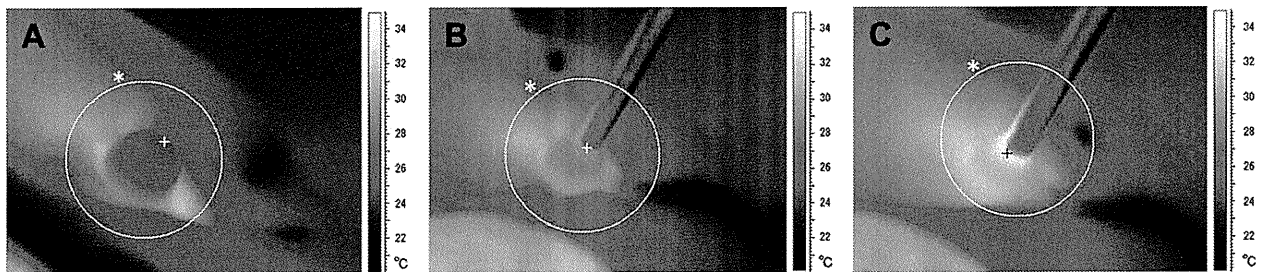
The thermographic images of ultrasound-treated eye by an infrared thermography. Temperature was expressed as a pseudo-color. (A) Control. The highest temperature within the circle (denoted by an asterisk) was 31.9°C and the temperature of the spot + was 24.4°C. (B) US exposure for 5 min under the condition: frequency of 1.0 MHz, duty cycle of 5.2%, pulse repetition frequency of 20 Hz and  $I_{SPPA,3}$  of 0.228 W/cm<sup>2</sup>. The highest temperature within the circle (denoted by an asterisk) was 31.2°C and the temperature of the spot + was 28.5°C. (C) US exposure for 5 min under the condition: frequency of 1.0 MHz, duty cycle of 100%, continuous wave mode and  $I_{SPPA,3}$  of 0.156 W/cm<sup>2</sup>. The highest temperature within the circle (denoted by an asterisk) was the area of the spot +, which was 33.7°C.
